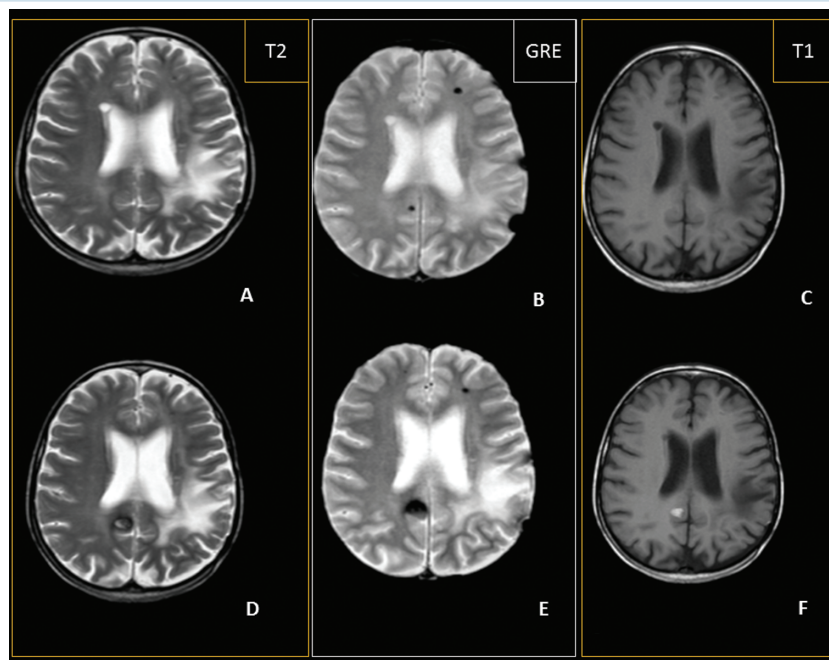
Follow-up brain MRI with gradient recalled echo (GRE)/ T2* sequence of a 27-year-old survivor of childhood primary brain tumor, showing evolution of a radiation-induced microbleed (1A–C) to a cavernoma (1D–F) in 20 months. Classification according to the current definitions.^{6,7}
